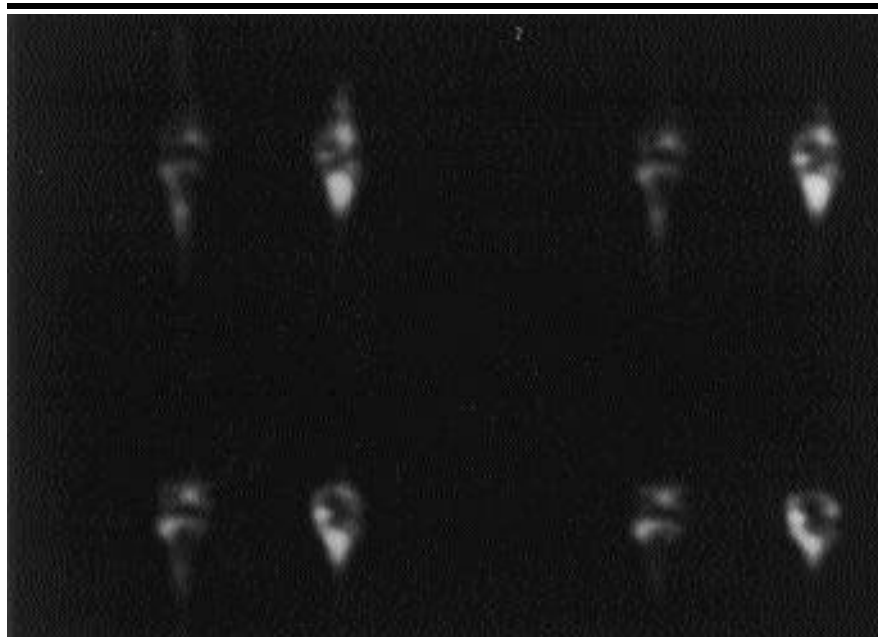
The coronal images of bone single photon emission computed tomography shows a large cold defect of bone uptake over the proximal tibia and distal femur with surrounding increased bone uptakes, suggesting bone infarction.
